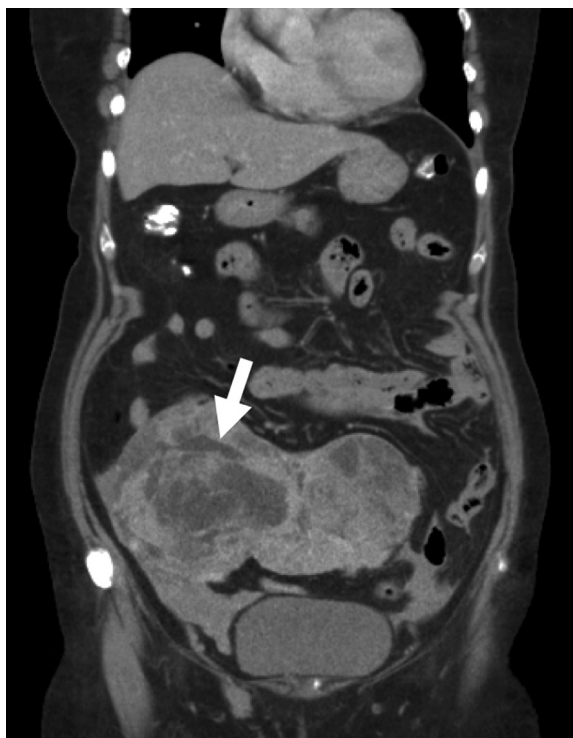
Contrast-enhanced abdominal computed tomography: a heterogeneous tumor, 18 cm × 15 cm × 10 cm in size, arising from the sigmoid mesocolon.
